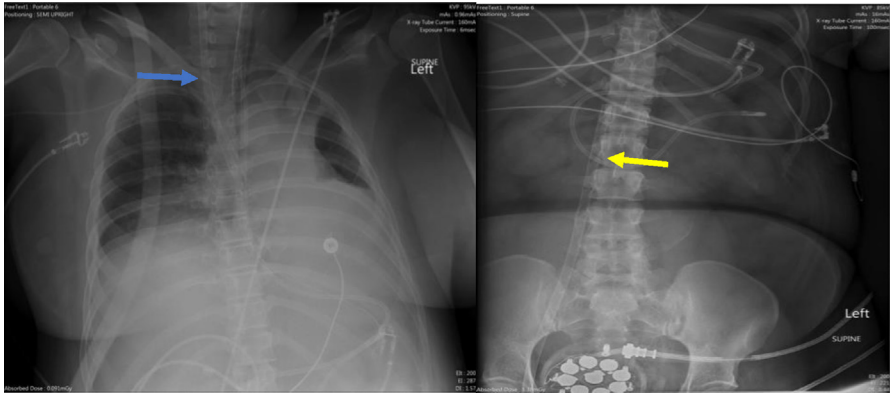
Chest and abdominal radiographs showing appropriate cannula placement. Outflow cannula in the image on left noted by blue arrow and inflow cannula in image on right noted by yellow arrow.
